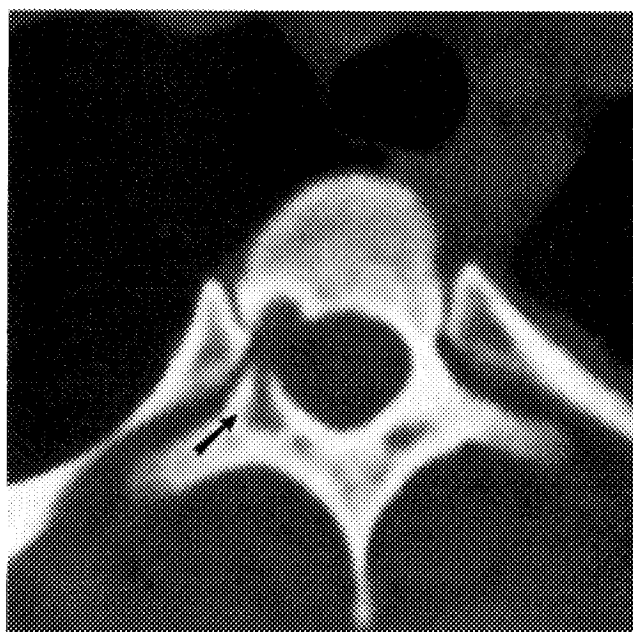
Axial CT section through the T3 pedicles reveals a well-circumscribed mass destroying the right pedicle (arrow) with a narrow zone of transition, sclerotic rim, and a homogeneous matrix denser than adjacent soft tissue and less dense than bone with no discrete calcifications.
